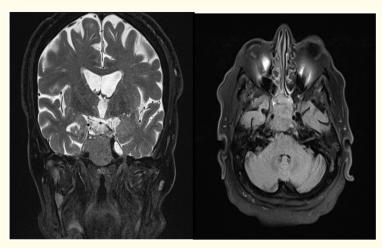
MRI with contrast showing no intracranial extension.
